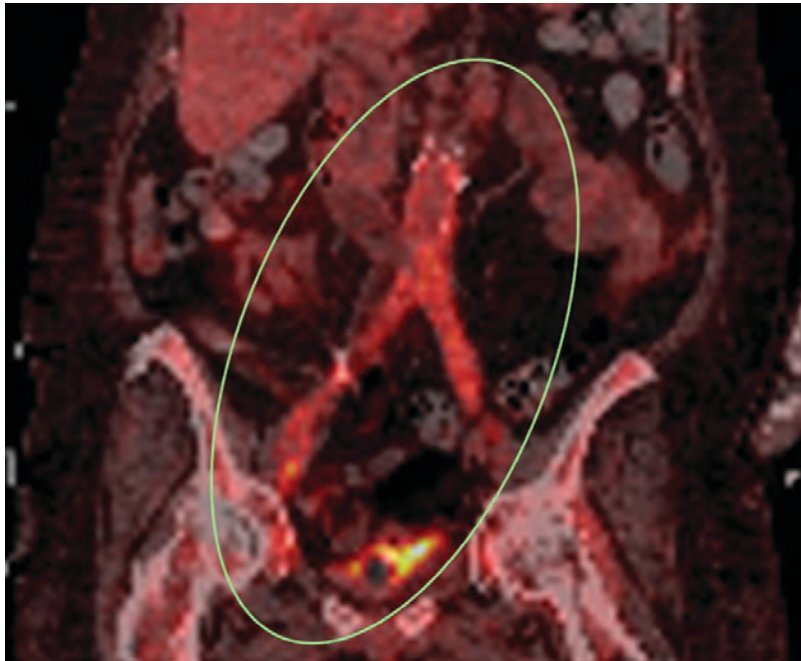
Coronal PET/CT coronal view demonstrates patchy FDG uptake throughout the entire aortoiliac bypass graft tracking into both groins, suggestive of infection/inflammation.
